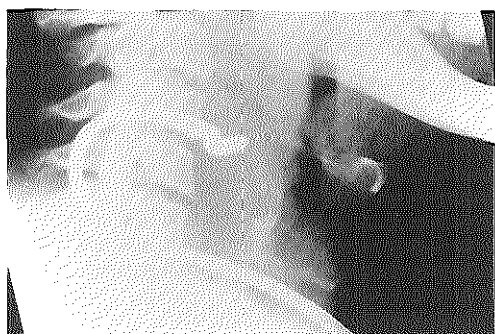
Lateral X-ray view of the neck. The tip of the catheter is in the prevertebral abscess.
